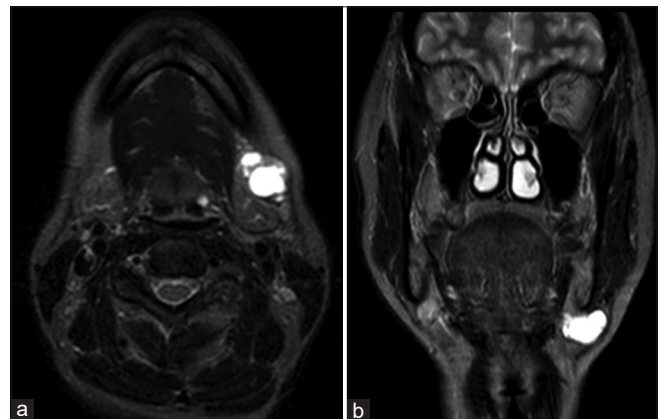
Magnetic resonance imaging scan. A circumscribed lesion sized $2.5 \times 1.7 \text{ cm}^2$, presenting adjacent to the left submandibular gland. (a) STIR sequence axial plane, (b) STIR sequence coronal plane
